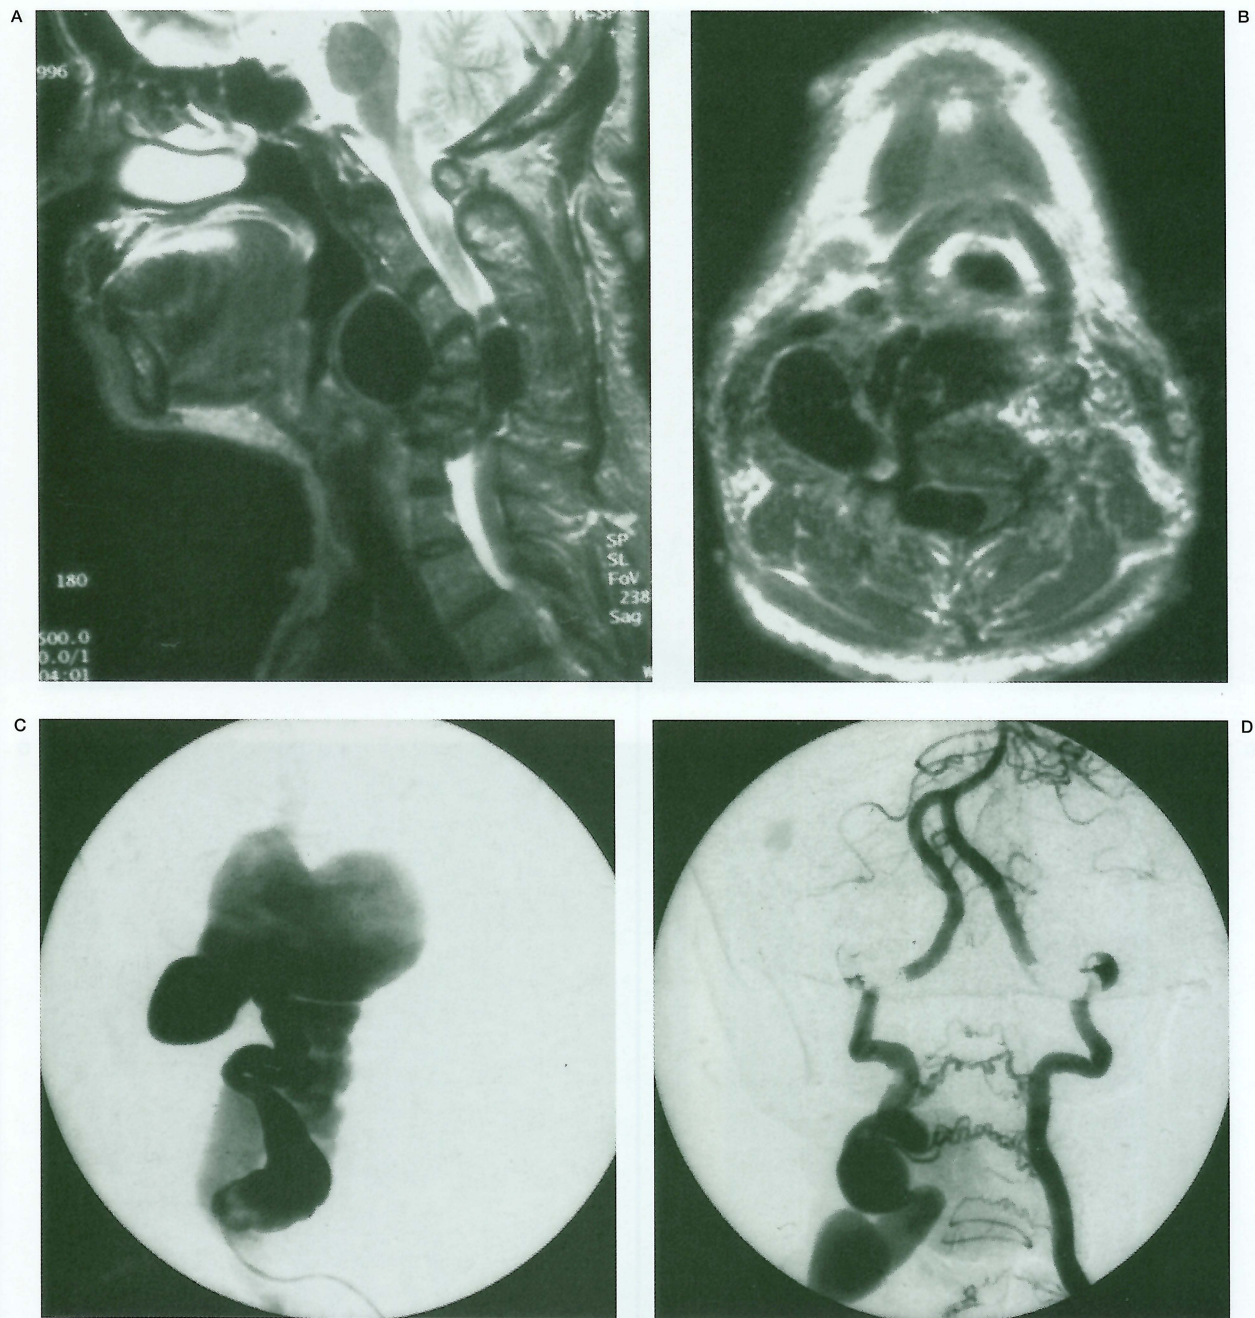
Case 5. A) Sagittal T2 weighted MRI demonstrating severe cervical kyphoscoliosis and intraspinal and prevertebral ovoid masses with flow void. B) Axial T1 weighted MRI showing severe spinal cord compression by a varix (white arrows) which is contiguous with prevertebral varices through the neural foramen. C) Right VAG, AP projection, showing a markedly tortuous and dilated VA, a fistula at C4 level and gigantic varices. D) Left VA injection showing a prominent steal phenomenon to the high flow right vertebral AVF. A result of a failed attempt to trap the vertebral AVF performed at an outside hospital.
